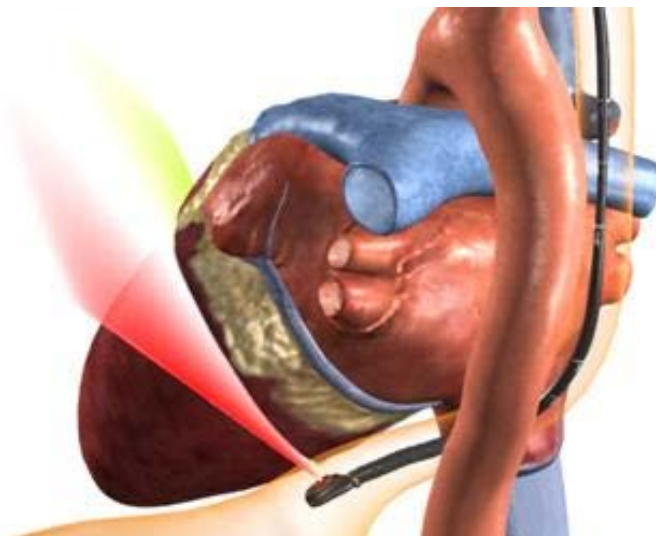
Transesophageal approach for atrial fibrillation treatment.
